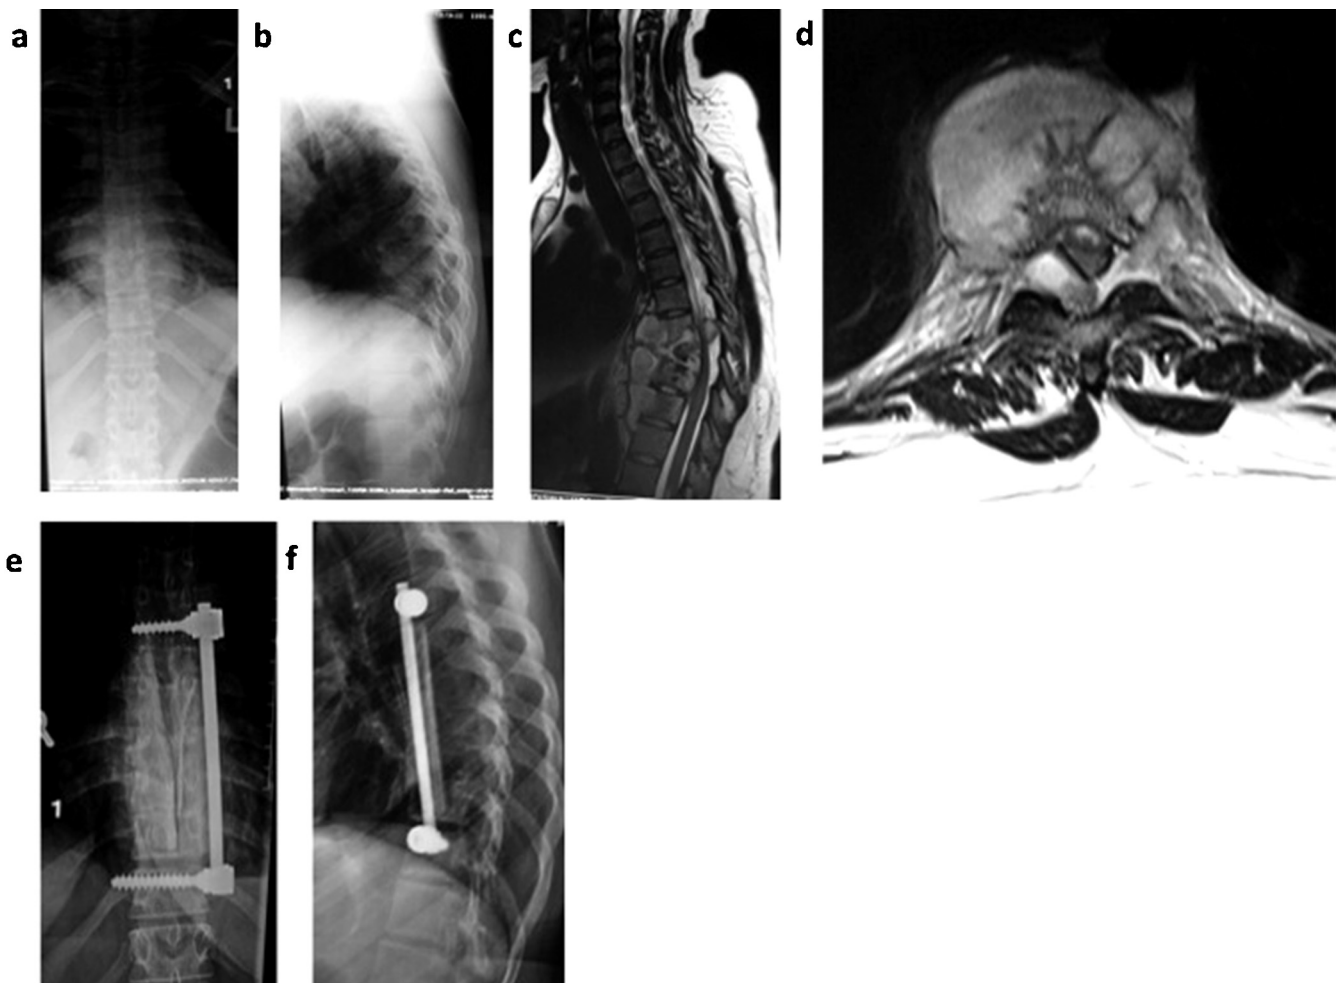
Patient 11, anterior corpectomy, strut graft and instrumentation. (a and b) Plain X-rays showing bony destruction at the mid-thoracic level. (c and d) MRI showing large abscess formation, compromise of the chord is visible in the sagittal and axial views. (e and f) Post-operative images.
